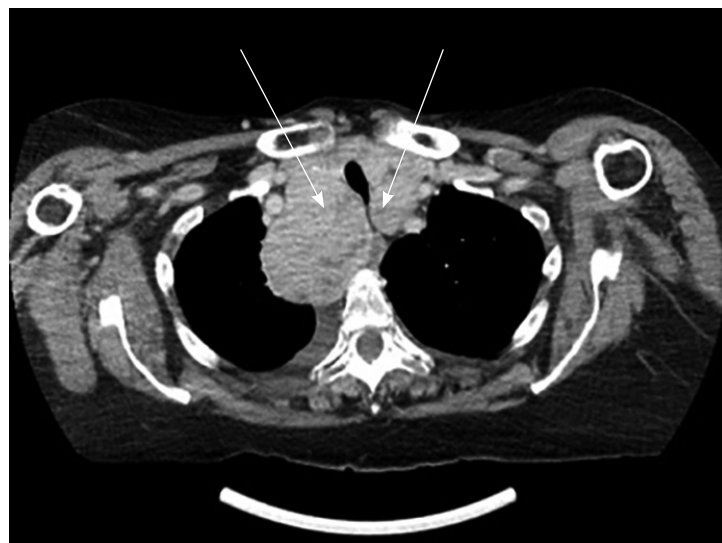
Computed tomography of neck and chest showing a grossly enlarged thyroid gland (arrows) with significant intra-thoracic extension causing tracheal narrowing.
